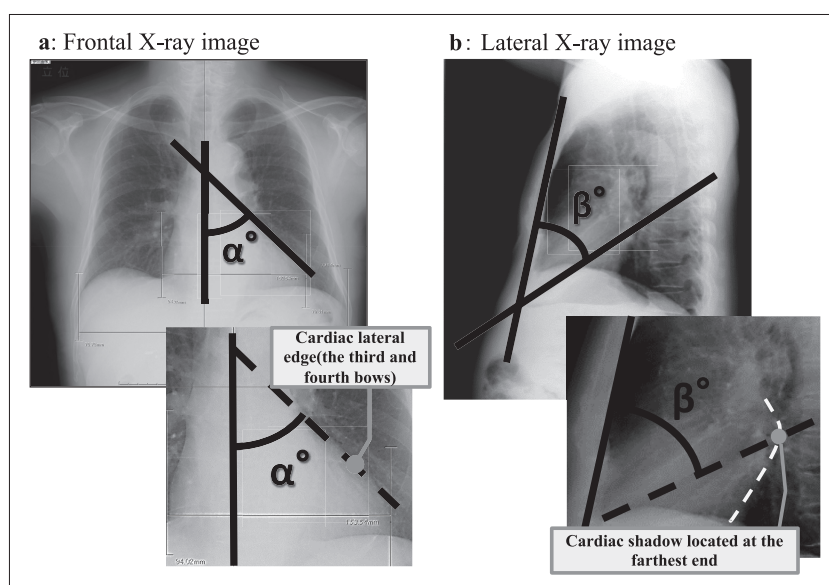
Measurement of cardiac shadow in chest X-ray image
